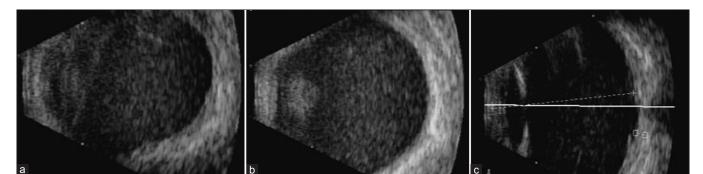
Serial ultrasound B-scans: (a) at presentation, (b) postoperative day 2 after first vitrectomy, (c) postoperative day 2 after second vitrectomy
